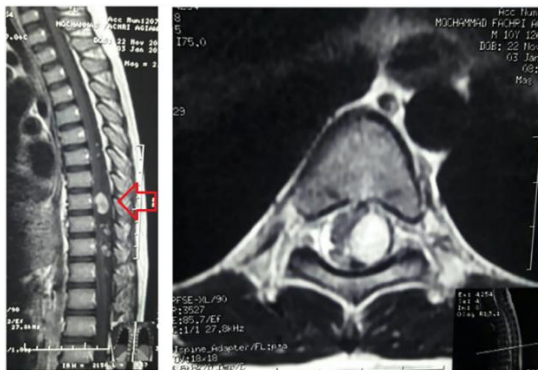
(A) MRI T2 sequence of the sagittal slice. (B) MRI T2 sequence axial slice. From the MRI, we can observe the intramedullary cyst as an extramedullary intradural tumor at the 9th thoracic vertebrae.
